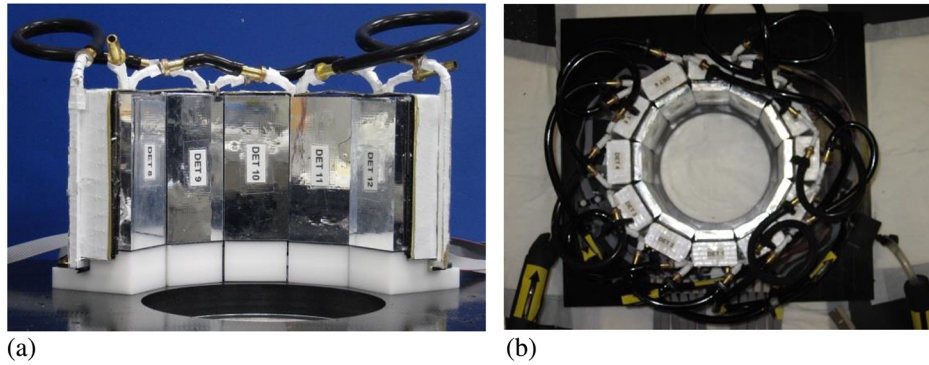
Picture of the PET component of the WVU-PET/MRI gantry showing the (a) close spacing of the detectors and (b) the completed ring of 12 detector modules with the cooling tubes (light tight cover removed).
